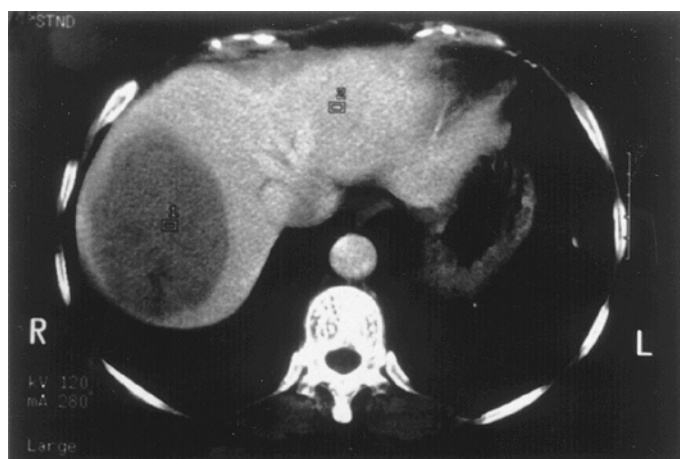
Computed tomography (CT) scan of abdomen showing a tumour-like mass of haemopoietic tissue in the liver in a patient with β thalassaemia intermedia. (With thanks to Dr S.K. Ma and W.Y. Au and by permission of the British Journal of Haematology.)
